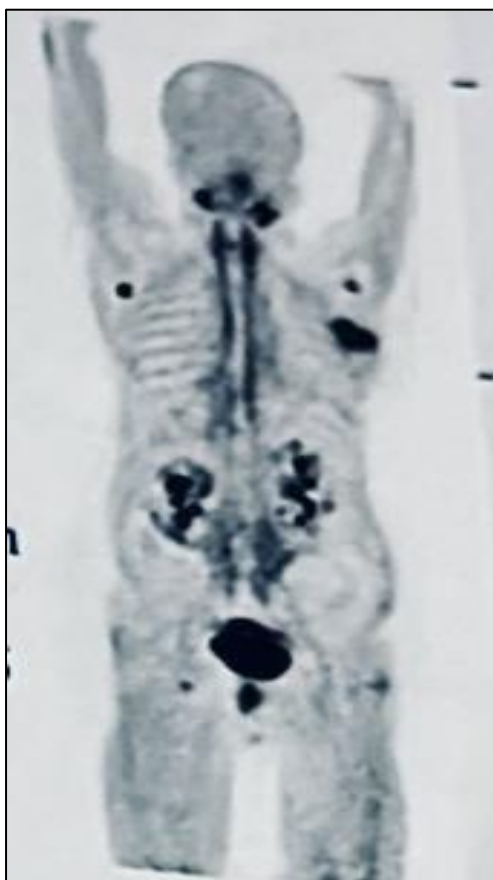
PET-CT showing bilateral enlarged kidneys showing polycystic morphology, hepatic cysts, few enlarged axillary, pectoral nodes and soft tissue lesion in both breasts and ovary.
